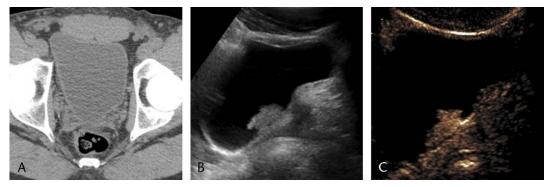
A, Nonenhanced CT performed on a 30-year-old man for hematuria and suspected renal colic demonstrates an unremarkable bladder. B, Gray-scale ultrasound image reveals a polypoid lesion arising from the bladder wall. C, Contrast-enhanced ultrasound depicts arterial phase hyperenhancement, concerning for a primary bladder neoplasm.
